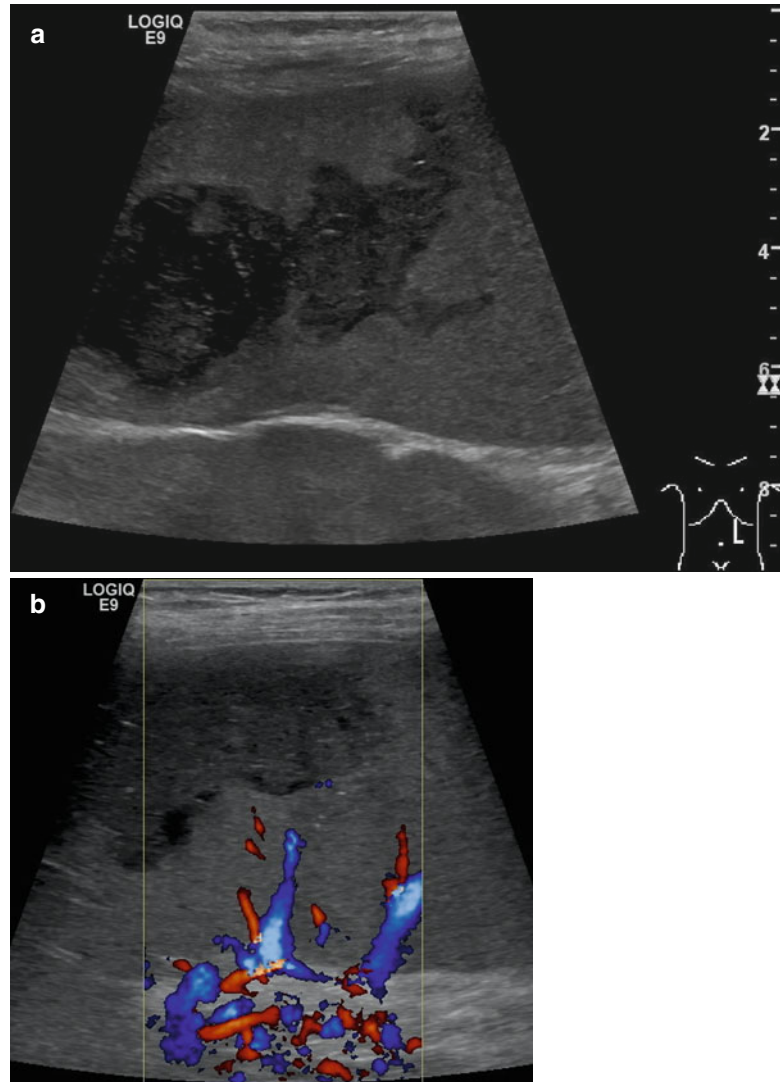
Splenic, hepatic and renal abscesses in a 17-year-old adolescent with chronic granulomatous disease (CGD). (a) Hypoechoic lesions (two of several abscesses) in the spleen. B-mode. Longitudinal section. (b) Bidirectional power Doppler sonography shows no perfusion within the abscesses. Same section
